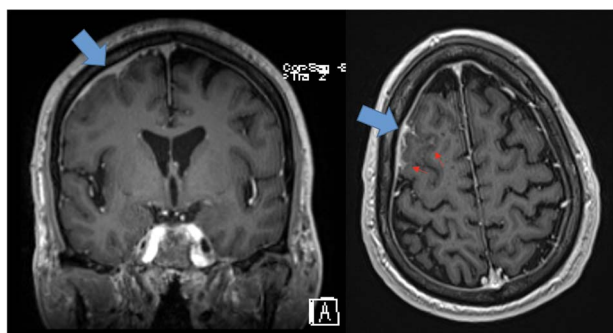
Initial MRI brain, blue arrows demonstrate Pachymeningeal enhancement along the right frontal lobe and red arrows demonstrate leptomeningeal enhancement.
